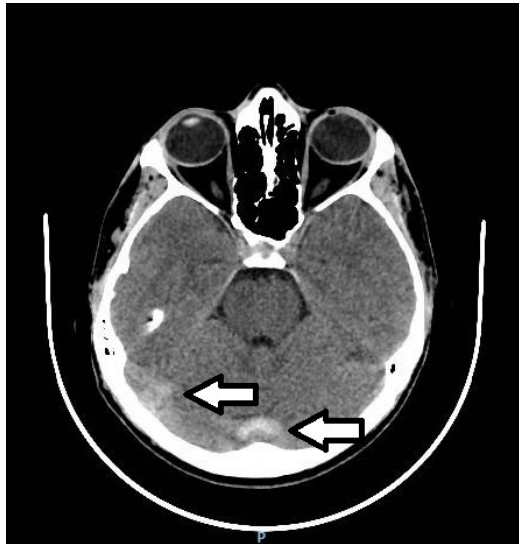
Right transverse sinus thrombosis and sigmoid sinus thrombosis – Computed Tomography
